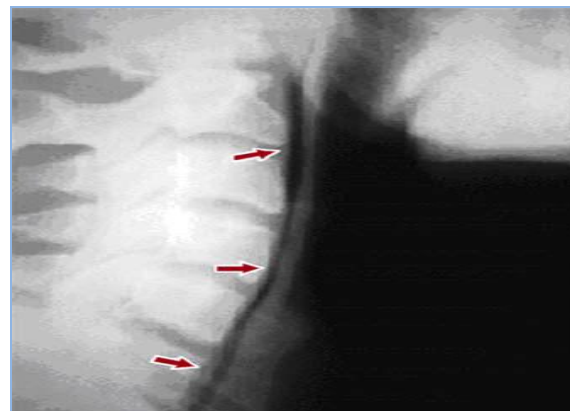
A lateral cervical-spine radiograph in a 19-year-old male college swimmer reveals air in the deep cervical tissues behind the trachea and larynx (arrows) posterior to the nasopharynx. (From Ferro RT, McKeag DB. Neck pain and dyspnea in a swimmer. Phys Sports Med 1999;27; with permission.)
